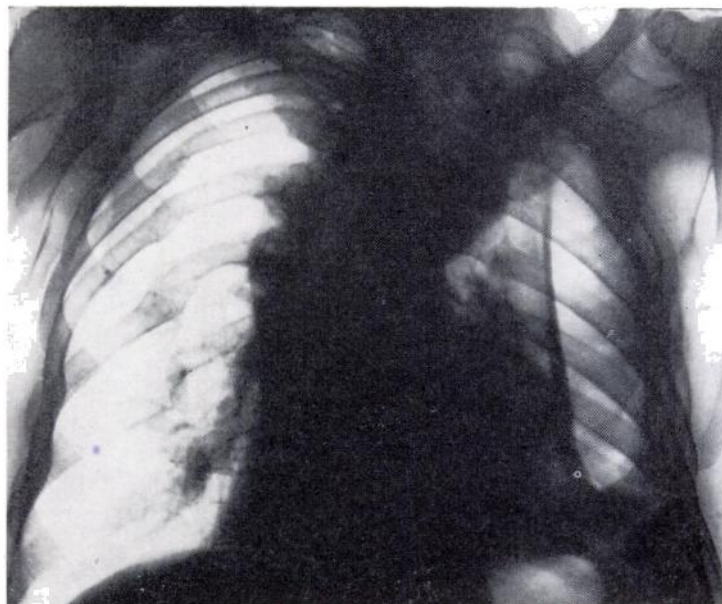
(CASE I): Chest x-ray film (July 7th, 1953), after emptying the pleural effusion: considerable thickening of the pleural surface at the left side over collapsed lung.
